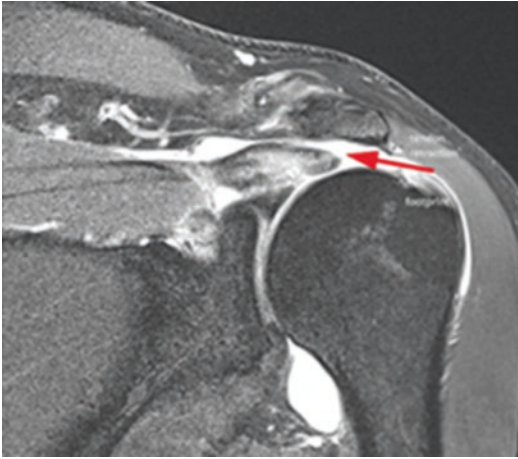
MRI imaging of an acute FTRCT
